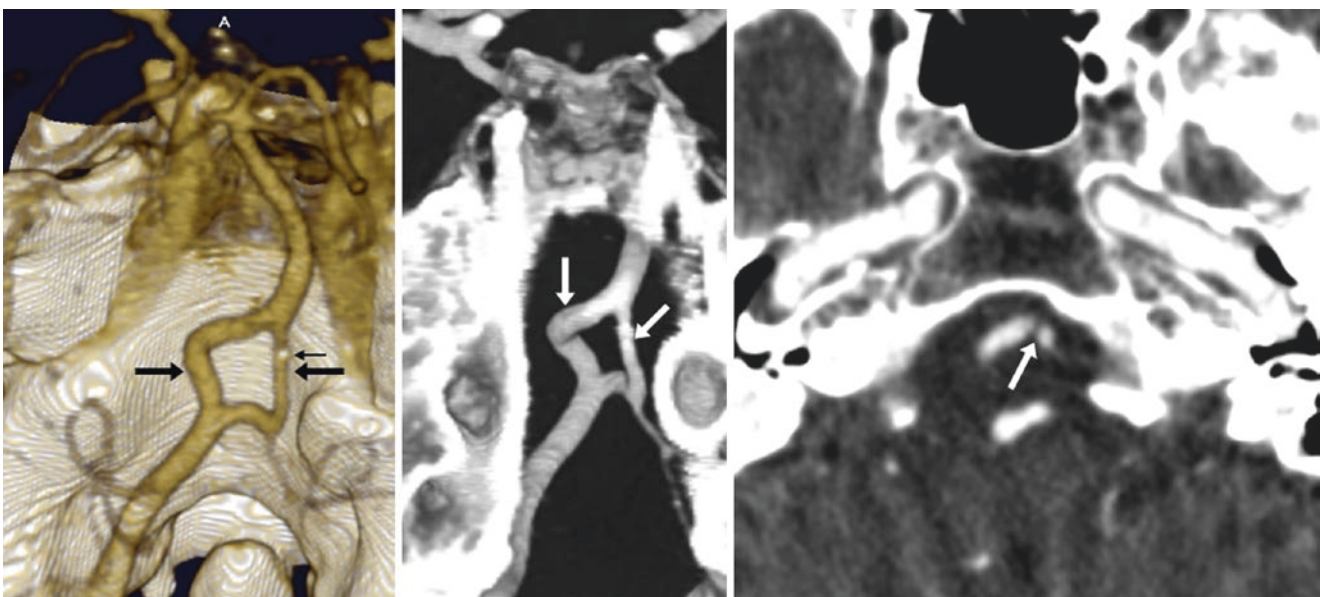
73-year-old with a sizable vertebrobasilar junction fenestration (*large arrows*) on a 3D VR CTA posterior view (*left*), coronal MPR (*middle*), and source axial image, which delineates the cleft (*right, arrow*). Note a tiny atherosclerotic calcification (*left, thin arrow*). The right VA was dominant; the left was quite tiny and hypoplastic
